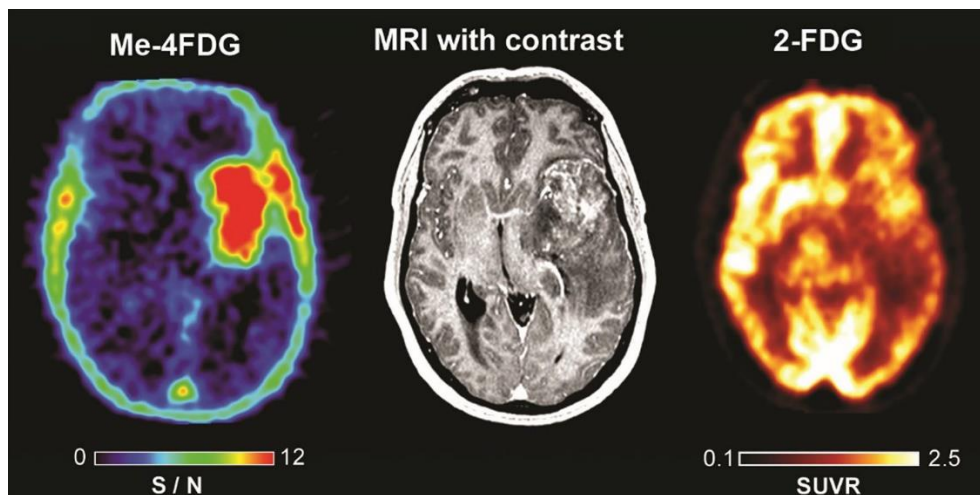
^{18}F -Me-4FDG PET (left), T_1 -weighted post-contrast (middle) and ^{18}F -FDG PET (right) images of a patient with an anaplastic astrocytoma, WHO grade III. The ^{18}F -FDG image shows mixed uptake within some portions of the mass, with highest uptake comparable to normal cortical uptake in the healthy contralateral cortex. The ^{18}F -Me-4FDG image, however, shows uniform tumor uptake without any uptake in the surrounding healthy brain parenchyma, providing significantly higher T/N ratio than the ^{18}F -FDG image. This figure is reproduced – with new figure legend appropriate for current book chapter – from Kepe et al. (2018), Figure 4, under the terms of the Creative Commons Attribution 4.0 International License (<http://creativecommons.org/licenses/by/4.0>) (48).
